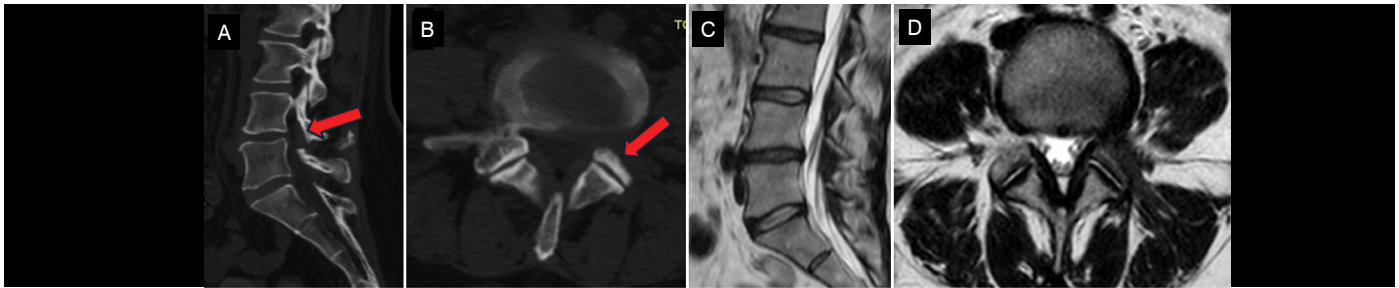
Sagittal (A) and axial (B) CT scans show adequate foramotomy (arrow); MRI shows residual L4-L5 protrusion (C, D).
